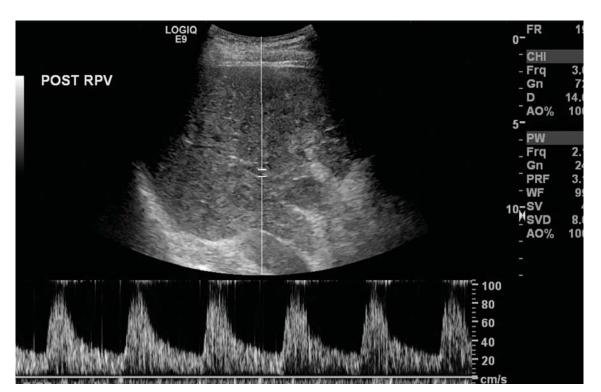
Pulsed-wave Doppler confirmed arterialisation of the areas of thrombus.
